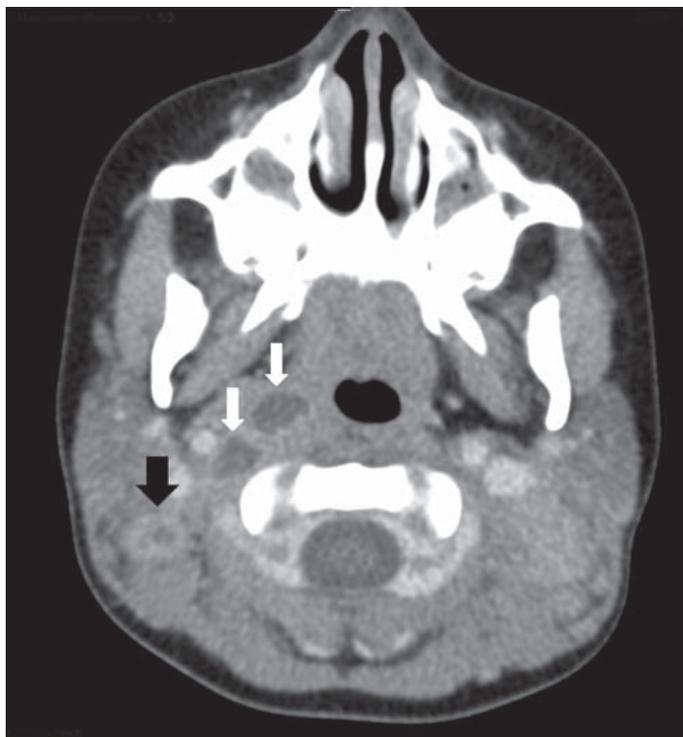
Computed tomography scan of the neck of a 3-year-old girl, showing right lateral retropharyngeal abscess (white arrows) and enlarged bilateral posterior cervical lymph nodes with low attenuation of a right cervical lymph node (black arrow), consistent with atypical mycobacterium adenitis.
